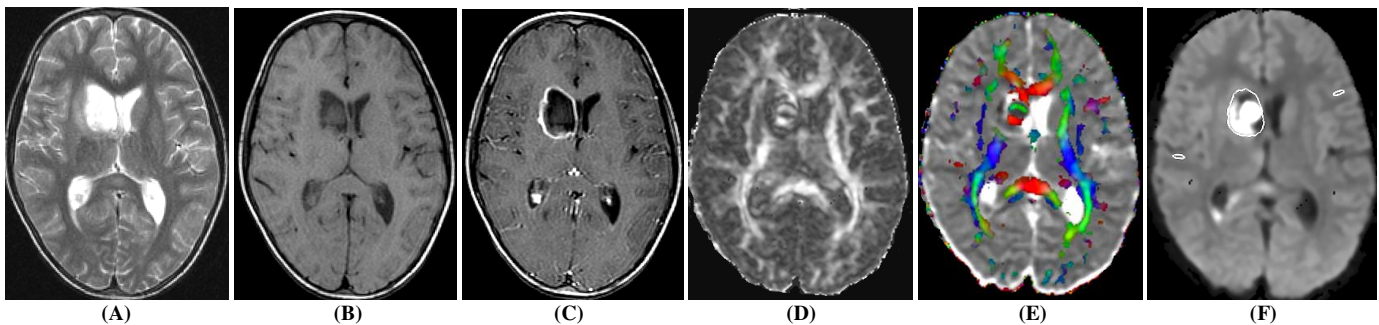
A 24-years-old male with right ear discharge and brain abscess with intraventricular rupture. T2 image (A) through the lateral ventricles shows hyperintensity in the right periventricular region. Corresponding T1 image (B) shows the lesion as hypointense that displays rim as well as meningeal enhancement on post contrast T1 image (C). FA map (D) shows areas of high FA values in the cavity mixed with intervening low FA values. Color modulated FA maps fused with D_{av} map shows (E) orientation in the abscess cavity similar to what is observed in the oriented white matter. DW image (F) show restricted diffusion in the cavity. The elliptical and free hand ROIs placed on DWI image (F) on cortical region as well as abscess cavity that was co-registered with figures 1A-E to get uncontaminated values of FA and MD.
